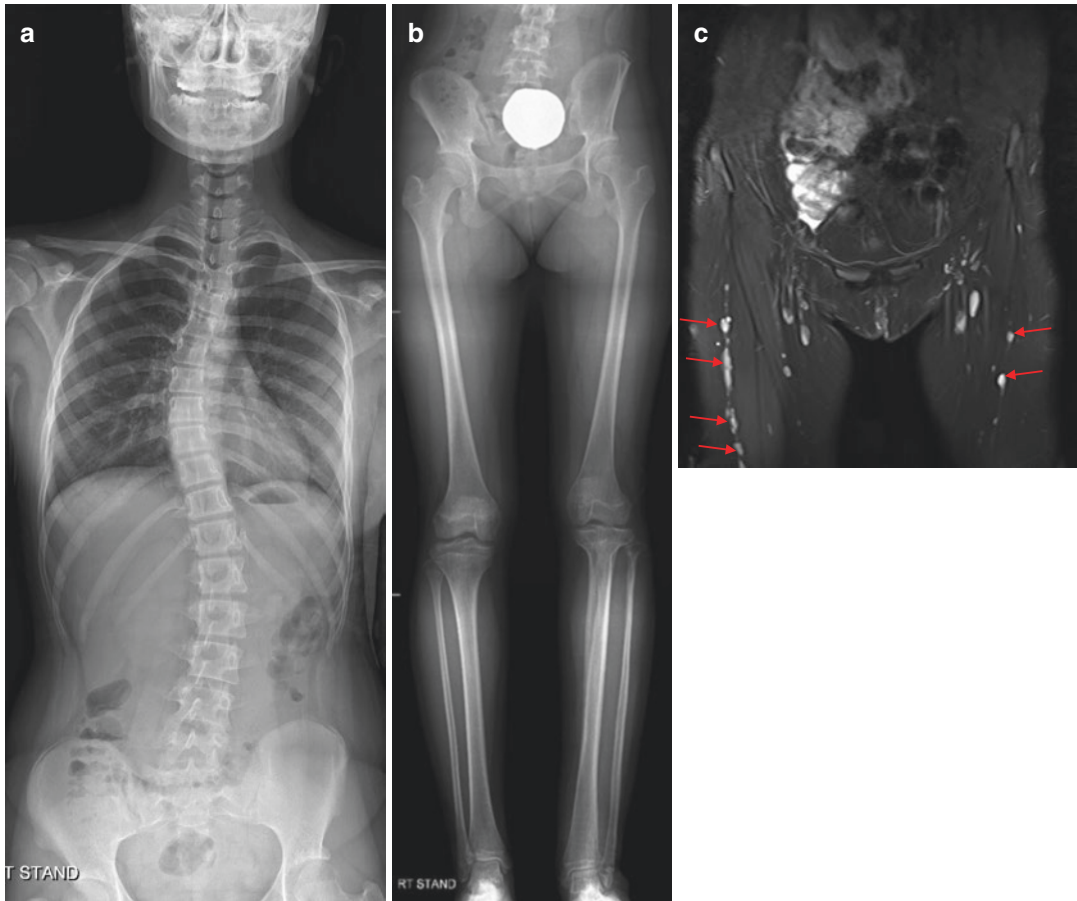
Neurofibromatosis type 1. Whole spine standing AP radiograph (a) shows a thoracic scoliosis. Teleradiograph of the lower extremity (b) reveals dysplastic left proximal tibia with irregular thick cortex and widening of the affected tibia. Coronal FS T2WI (c) shows multiple, circumscribed, oval hyperintense soft tissue lesions (*thin arrows*) along the nerve courses in both thighs. Sagittal FS T2WI (d) of the lower leg shows a typical appearance, diffuse thickened nerve with nodularity, of plexiform neurofibroma affecting the common
